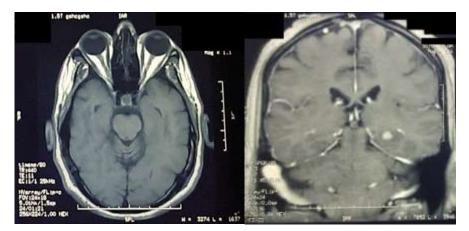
Brain MRI showed left temporal nodular lesion with gadolinium enhancement and vermian T2-Flair hyperintensities.
